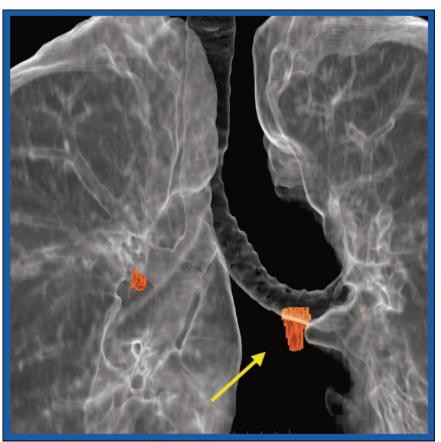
2005 SNM Image of the Year. Three-dimensional PET/multislice CT fusion image of virtual bronchography for presurgical evaluation. Note the ¹⁸F-FDG-avid lymph node "hiding" behind bronchus.
